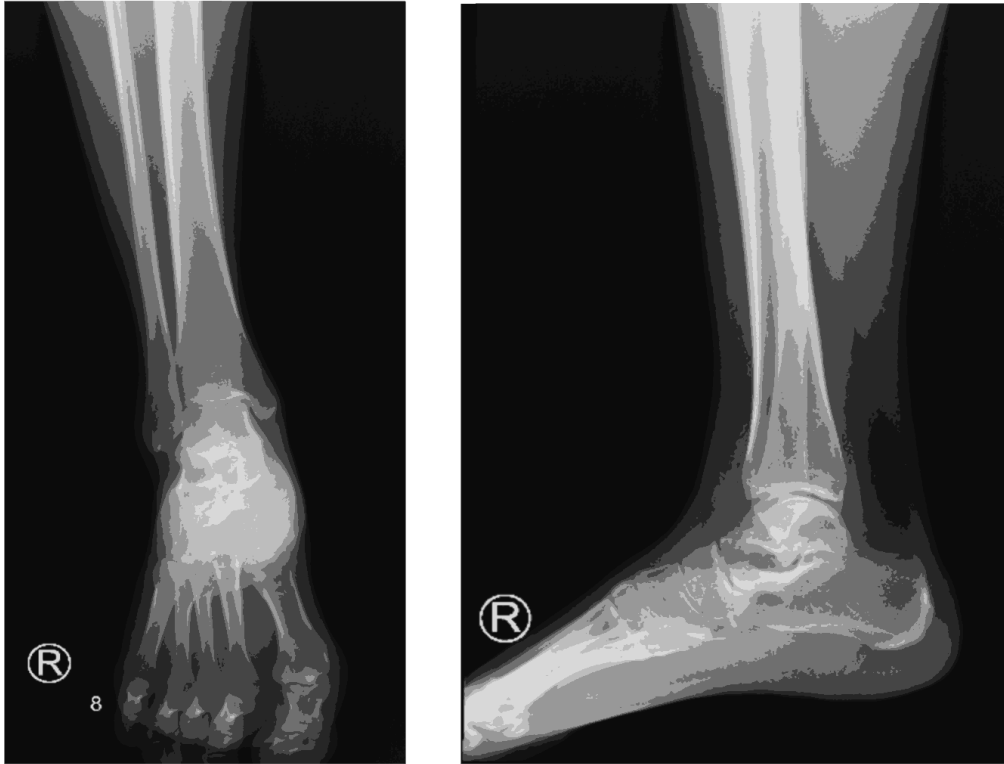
Right Ankle X-Ray AP/Lateral View.
